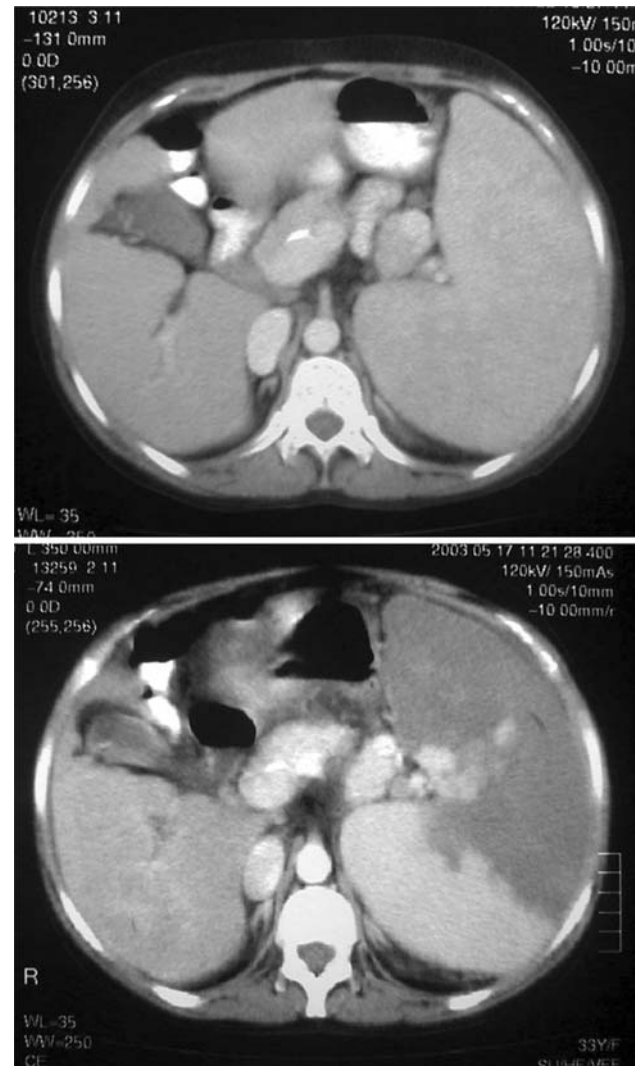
Computed tomography (CT) scan of the abdomen with intravenous and oral contrast before embolization (a) and 2 weeks after partial splenic embolization (PSE). The infarcted area of the spleen is the low-density region
